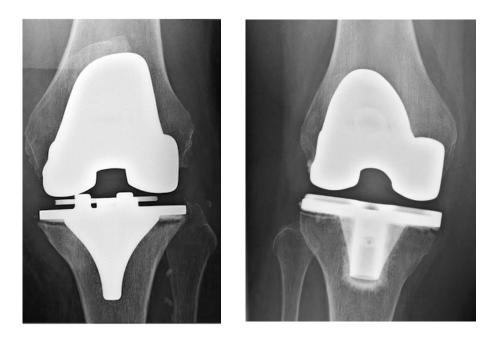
Radiolucent lines on postoperative X-ray's below both sides of the tibial base plate
